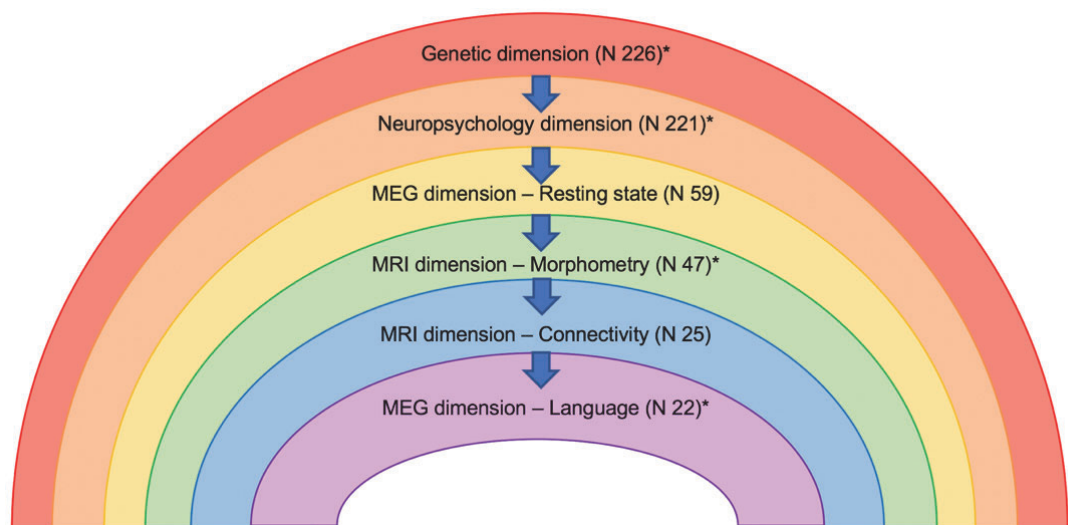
Structure of the multidimensional-multilevel-multimodal data acquisition, where each dimension of data is acquired in progressive levels, by using different modalities: from DNA sampling to neuropsychology and behavioural tests, magnetic resonance imaging (MRI) and magnetoencephalography (MEG). *Dimensions on which the empirical chapters focus.
